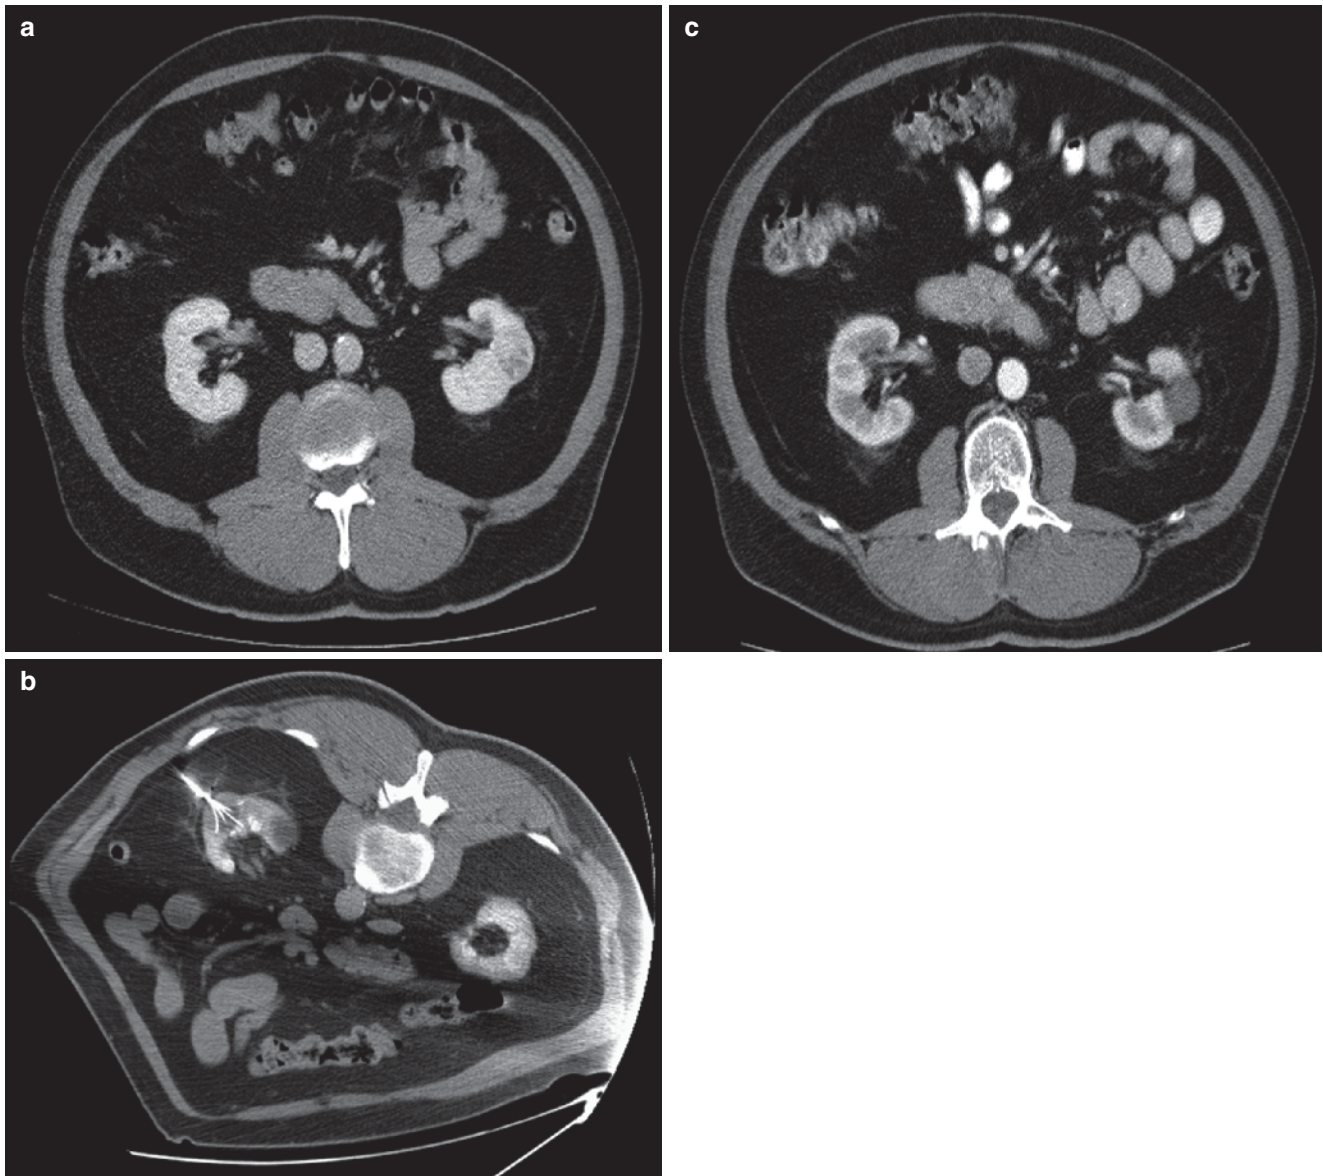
(a) Pretreatment contrast enhanced CT scan demonstrates a 2.7 cm enhancing renal mass in the mid pole of the left kidney. (b) Intraprocedural CT scan with patient placed in the prone position. The multitined RITA electrode is deployed to achieve an ablation zone
